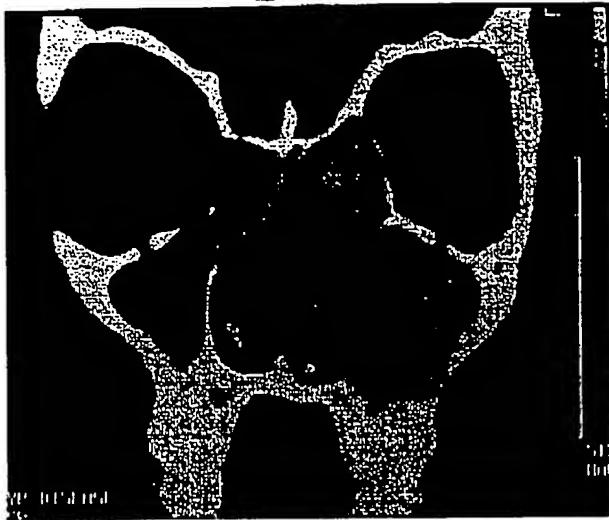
Coronal CT scan demonstrating areas of signal heterogeneity within sinuses filled with allergic fungal mucin.
